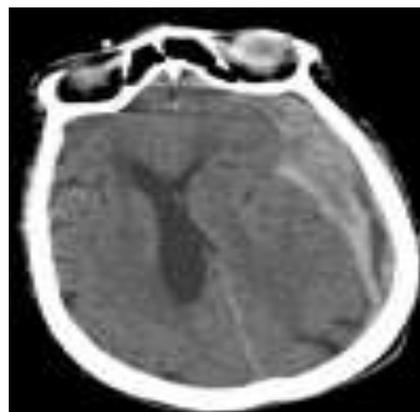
CT of an 87-year-old female status post fall showing a large subdural hematoma along the left cerebral convexity with significant midline shift and effacement of the left lateral ventricle.
